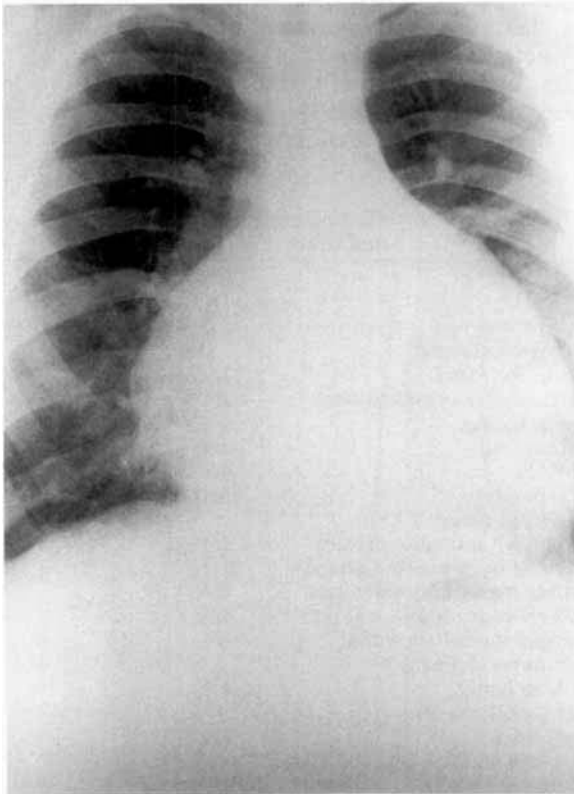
Chest radiograph showing pericardial effusion and cardiomegaly.
